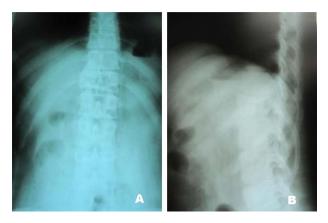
Case 1, (A): Anterior-posterior; (B): Lateral pre-operative X-ray.
